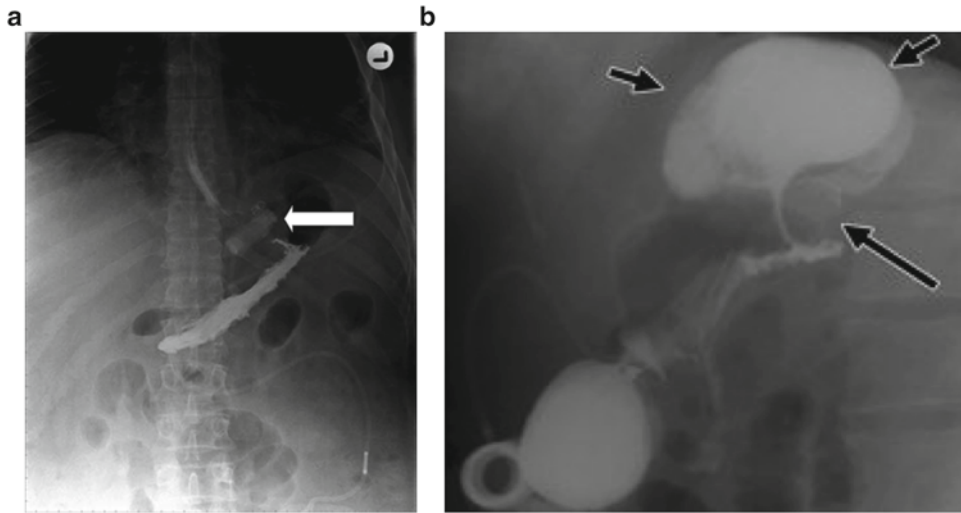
(a, b) Easily seen radiographic findings that may indicate the presence of a slipped band include the presence of an “O” sign (the circular ring of the band easily
